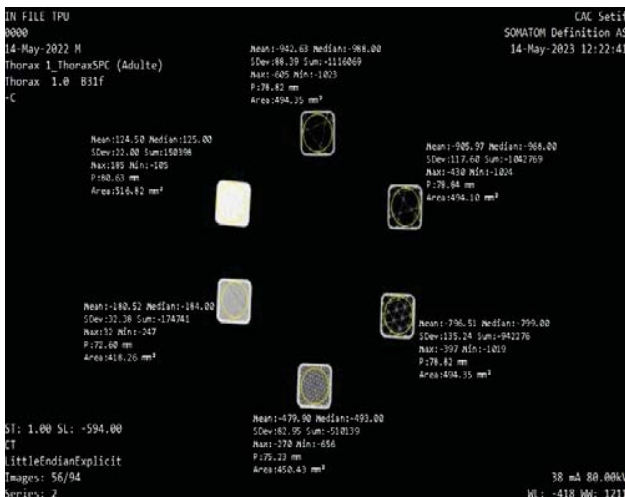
CT-scan slice of different TPU 3D printing samples with different filling rates
